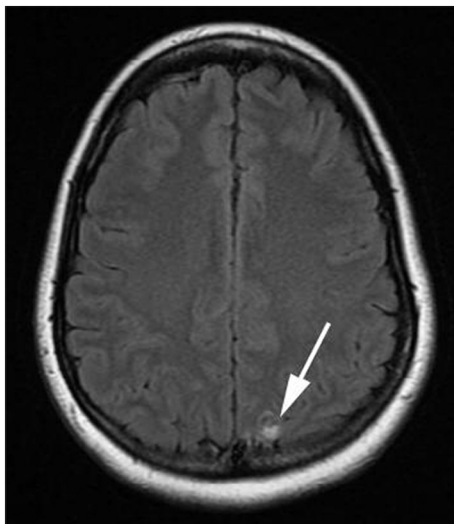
Fluid attenuation inversion recovery MRI image of the brain demonstrating focal high signal in the posterior left parietal lobe in the same location as the ring enhancing metastasis in Fig. 2.
